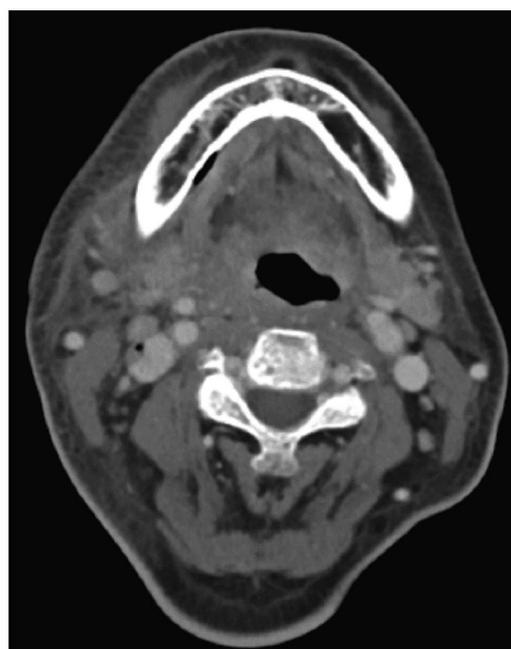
Axial CT image with contrast enhancement at C1 level shows an intact internal jugular vein.
